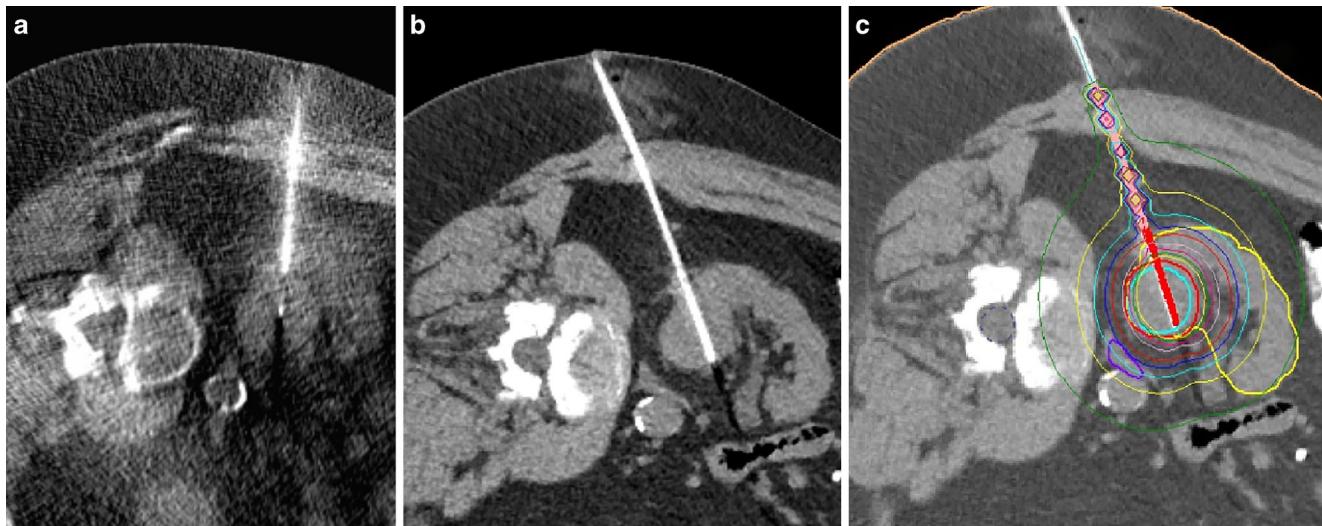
Image data set of Computed tomography-guided brachytherapy for a renal cell carcinoma: a Computed tomography fluoroscopy, image-guided insertion of a coaxial needle for biopsy and subsequent catheter placement; b diagnostic computed tomography displaying the catheter sheath within the renal mass; c irradiation plan depicting the tip of the iridium-192 source (red line) and corresponding isodoses for radioablation
